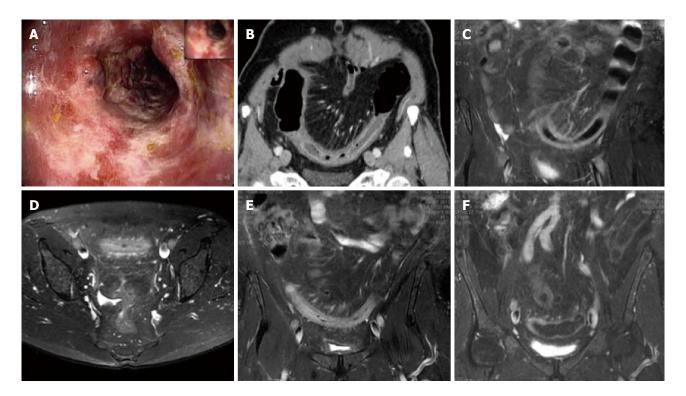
Magnetic resonance imaging follow-up of a patient with ischemic colitis and worsening of clinical symptoms. Ischemic colitis (IC) of sigmoid colon in a 62-year-old man with left lower quadrant pain and elevate lactate dehydrogenase levels, who presented with melena and a recent history of stenting procedures for ischemic cardiopathy. A: Endoscopic procedure showed multiple necrotic area; B: 2D (two dimensional) coronal reformat contrast-enhanced computed tomogra-phy (CT) showed acute IC (Type I CT); C-E: The patient had 2 magnetic resonance examinations (C and D-E) with an interval of 48 h due to worsening of clinical symptoms, with an increase of the length and thickness of the involved tract (D-E); F: The ischemic process resolved without complication after parenteral nutrition, as showed in the follow-up magnetic resonance imaging, performed after 384 h from the date of CT examination.
